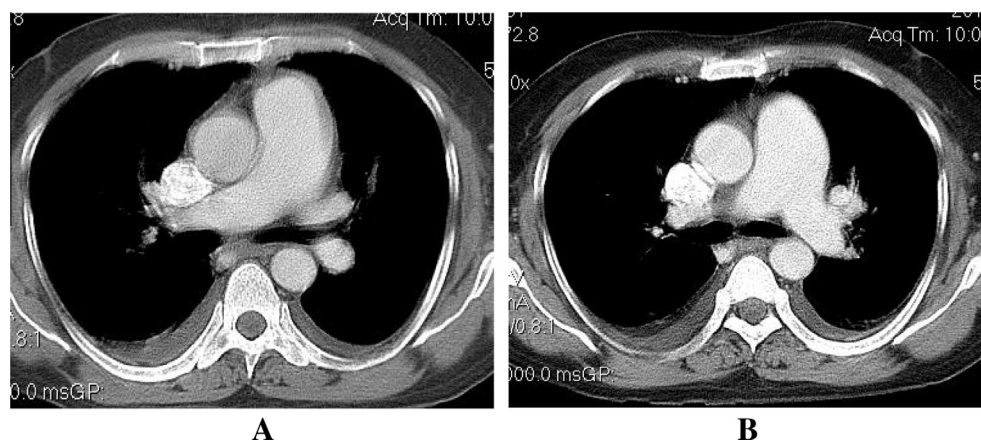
(A and B) Axial IV contrast CT scan chest showing enlarged main pulmonary trunk and the major right and left divisions, consistent with pulmonary hypertension.
